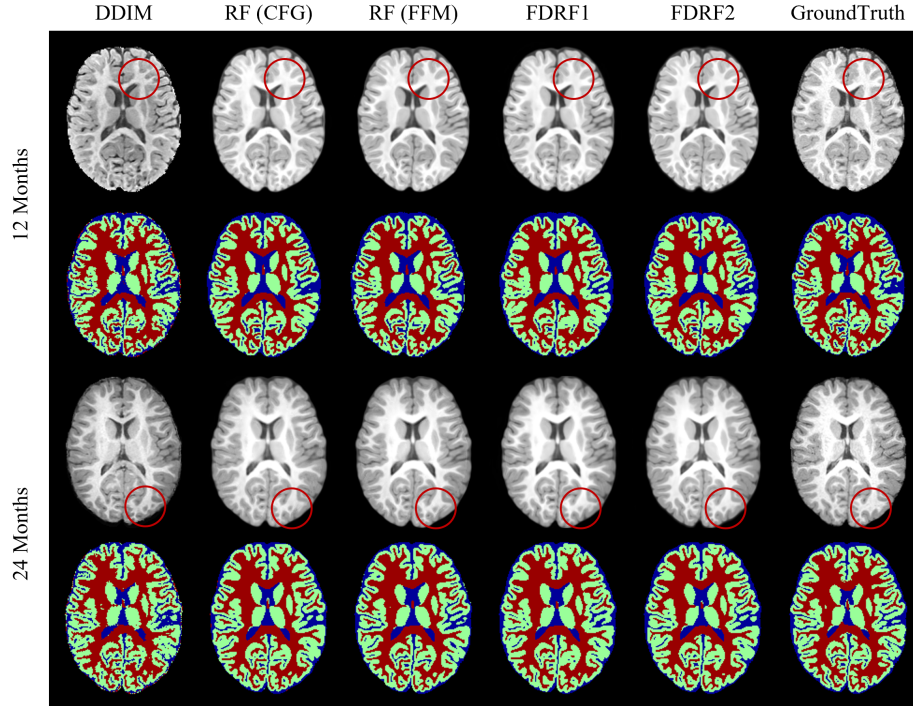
The upper part shows the brain MRI image and tissue segmentation of IBIS1048 generated at 12 months, while the lower part corresponds to those at 24 months.
